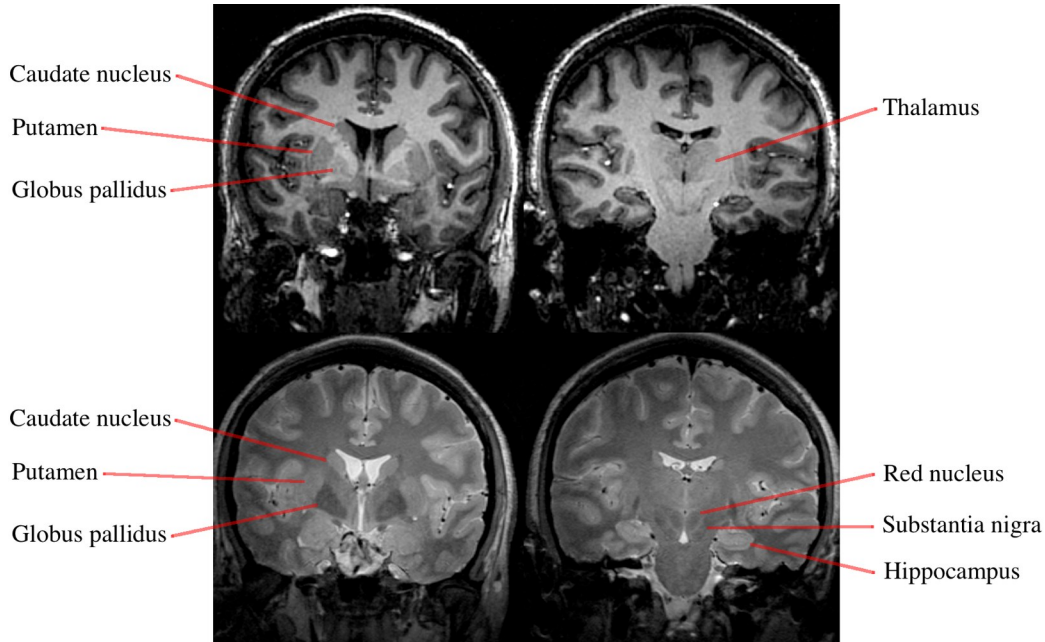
Coronal T_1 (top row) and T_2 (bottom row) weighted magnetic resonance images showing several deep gray matter structures.
